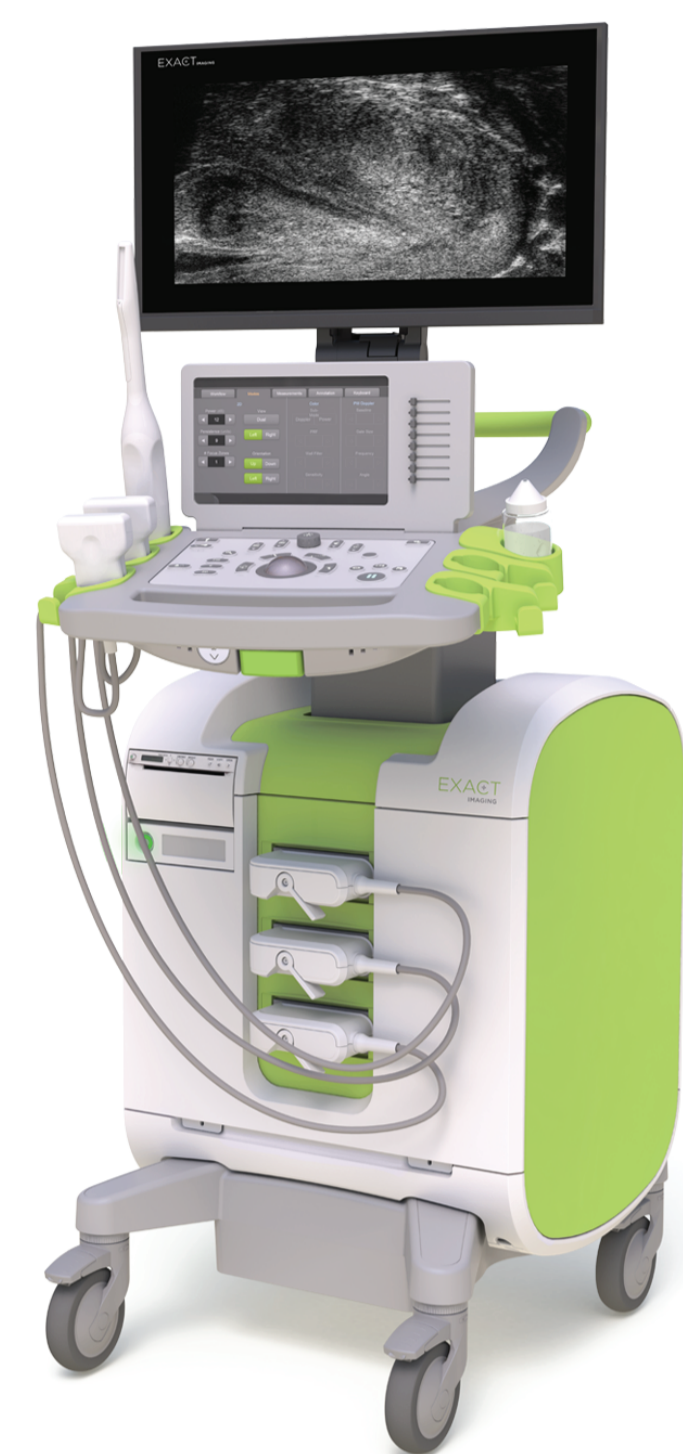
Exact Imaging's ExactVu™ 29 MHz Micro-Ultrasound System
